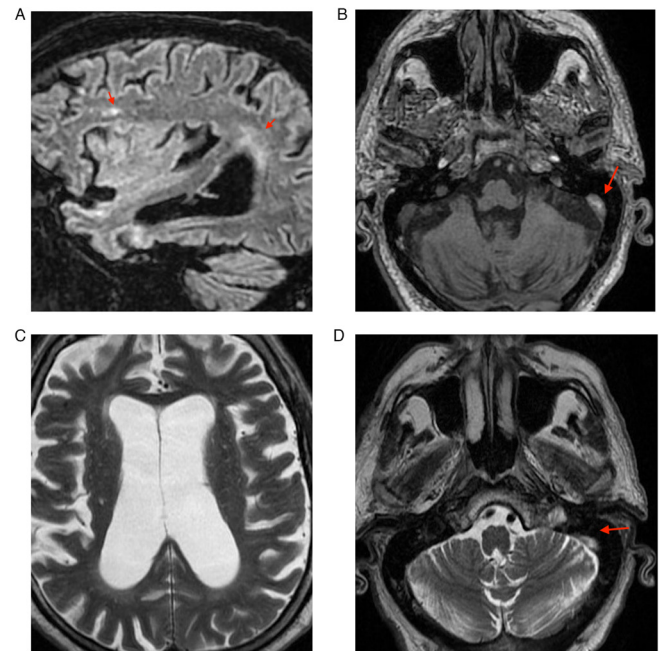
Case 1. (A) MRI scan highlighting supratentorial demyelinating lesions (fluid-attenuated inversion recovery-small red arrows); (B) left subacute venous transversal-sigmoid-jugular thrombosis (T1 hyperintensity-red arrow); (C) cerebral abiotrophy outside of the physiological range (T2); (D) left subacute venous transversal-sigmoid-jugular thrombosis (T2 hyperintensity-red arrow).
